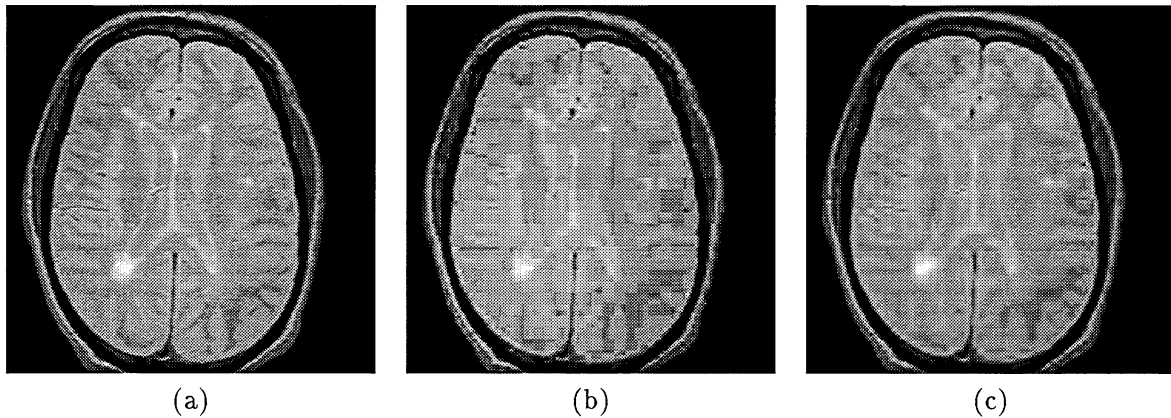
(a) The original MR image slice. (b) The JPEG-coded image reconstructed at 0.25 bpp. (c) The EZW'-coded image reconstructed at 0.25 bpp.
